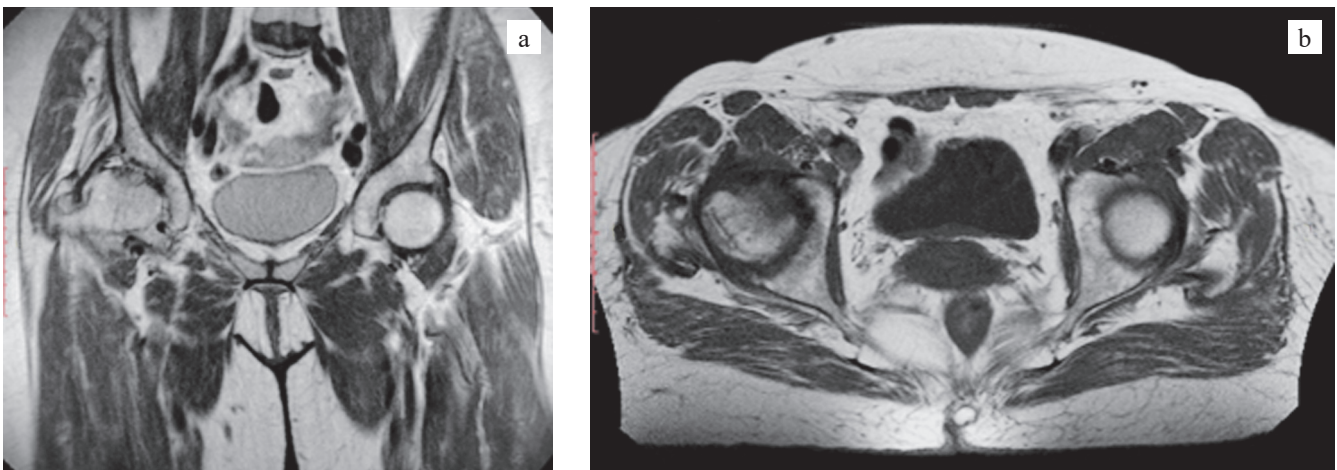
MRI of the right hip joint showing the FHAN area: a, frontal projection; b, axial projection
